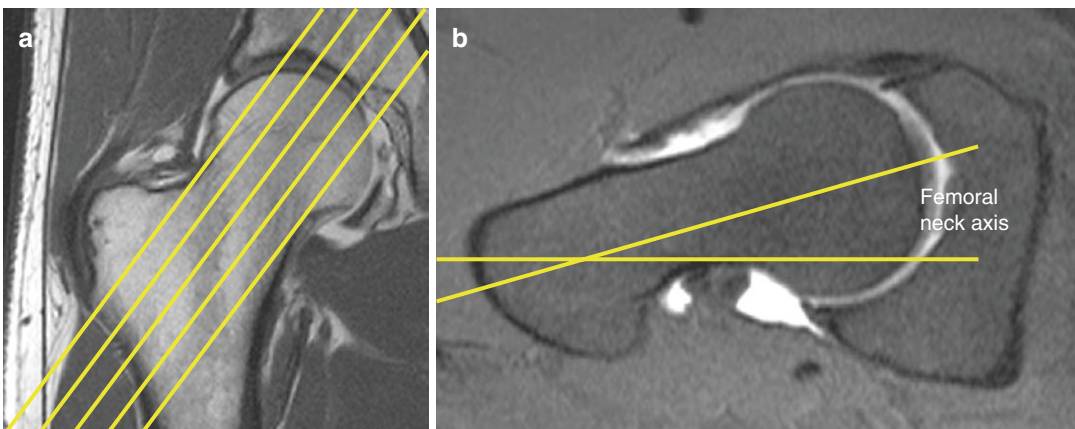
MRI determination of the femoral neck axis. (a) A coronal scout view with the lines of reference running along the plane of the femoral neck. (b) An axial oblique image of the femoral neck showing the neck axis
